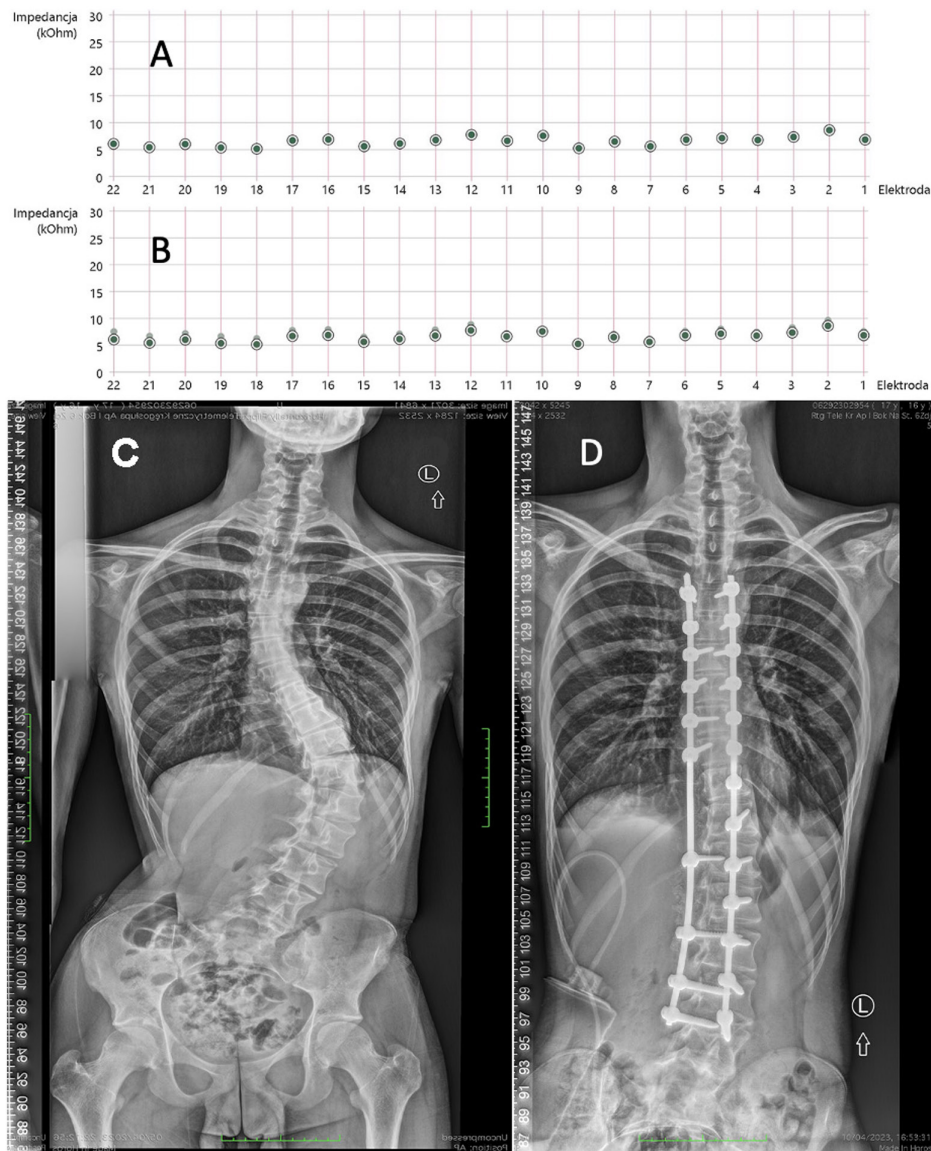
A. Measurement of electrode impedance before surgery; B. measurement of electrode impedance after surgery; C. X-ray of the spine before surgery; D. X-ray of the spine after surgery.
